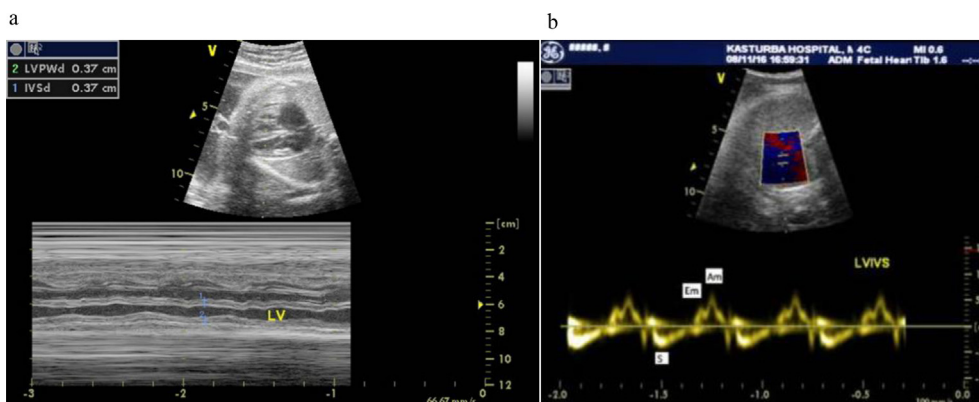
a.)M-mode across LV and RV adjacent to AV valves; the measurement displays Inter ventricular thickness in diastole and LV wall thickness in diastole. b.)Tissue Doppler imaging; Em: Early diastolic tissue annular velocity; Am: Late diastole tissue annular velocity during atrial contraction phase; S: systolic tissue annular velocity.
